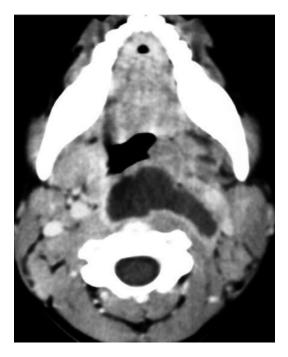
CT scan (with contrast) showing CT findings more consistent with an abscess rather than a phlegmon. Note the larger size, the rim of contrast enhancement
